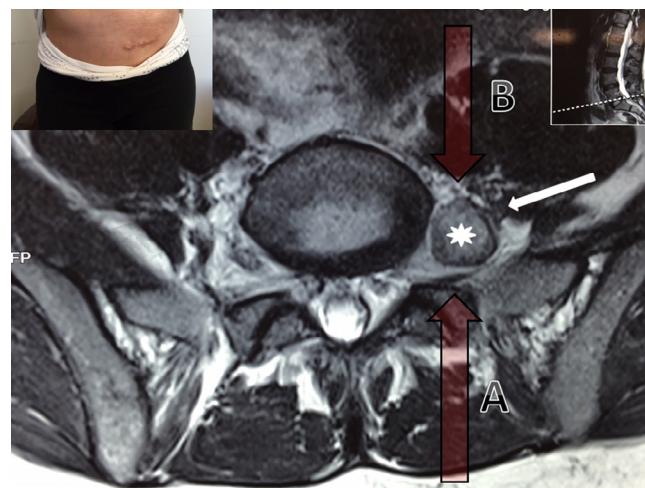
Axial T2WI magnetic resonance imaging (MRI): Foraminal schwannoma (asterisk). L5 nerve pushed laterally by lesion (white arrow). (A) Potential posterior approach with facetectomy to resect lesion. (B) Potential anterior approach to resect lesion. Inset demonstrates location and size of incision for the described approach.
